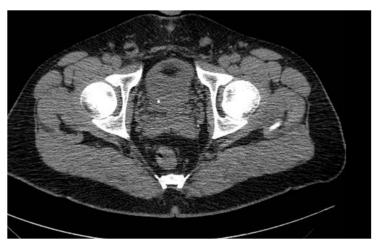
In axial image of non-contrast CT scan showed a 3-mm calculus lodged in the right ureterovesical junction
